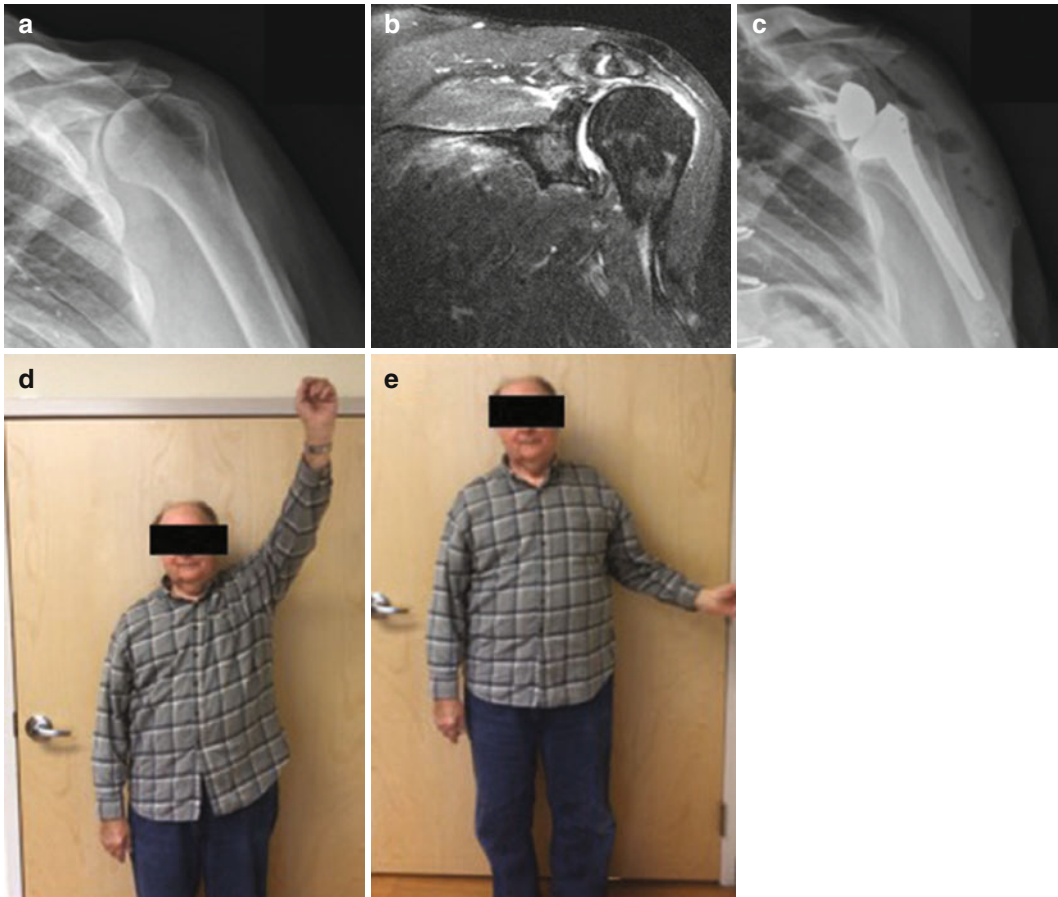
Preoperative radiograph demonstrating Hamada grade 4a rotator cuff arthropathy (a) and MRI demonstrating a retracted massive rotator cuff tear (b). Postoperative radiograph after placement of a reverse total
